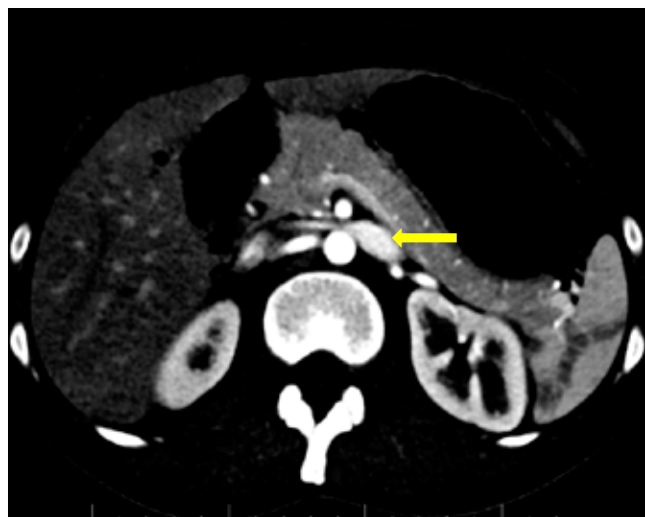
CT-venography findings of the left renal vein compression. Beak sign of the left renal vein (archive of the VUSCH).
